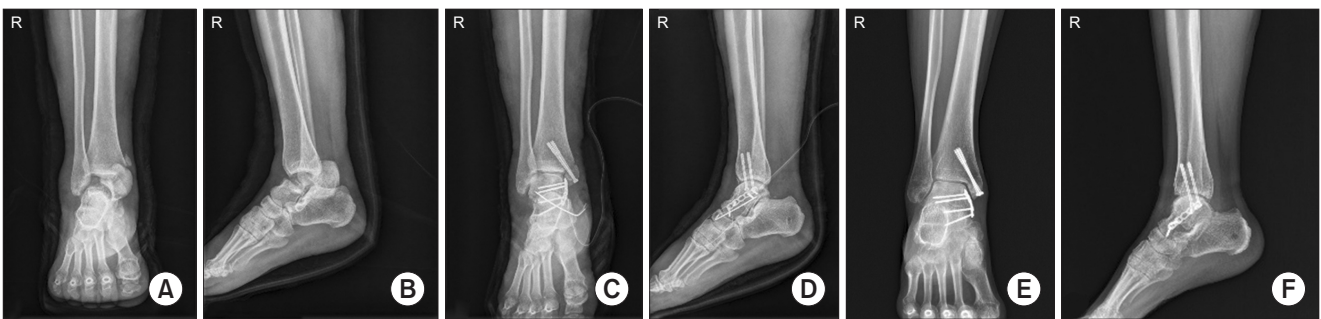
A 48-year-old woman who sustained a Hawkins's type III talar neck fracture with associated tibiotalar and subtalar dislocations in a traffic accident. (A, B) Preoperative anteroposterior and lateral radiographs. (C, D) Postoperative anteroposterior and lateral radiographs. Emergency surgery was performed on the same day, and open reduction was carried out through a single approach (anteromedial). Medial malleolar osteotomy was performed, and the fracture site was identified using a large distractor. Subsequently, internal fixation was conducted using a miniplate. (E, F) Anteroposterior and lateral radiographs at 1 year postoperatively. Complete bone union was observed, and posttraumatic osteoarthritis was observed in the subtalar joint, characterized by joint space narrowing, sclerotic changes, and the presence of osteophytes.
